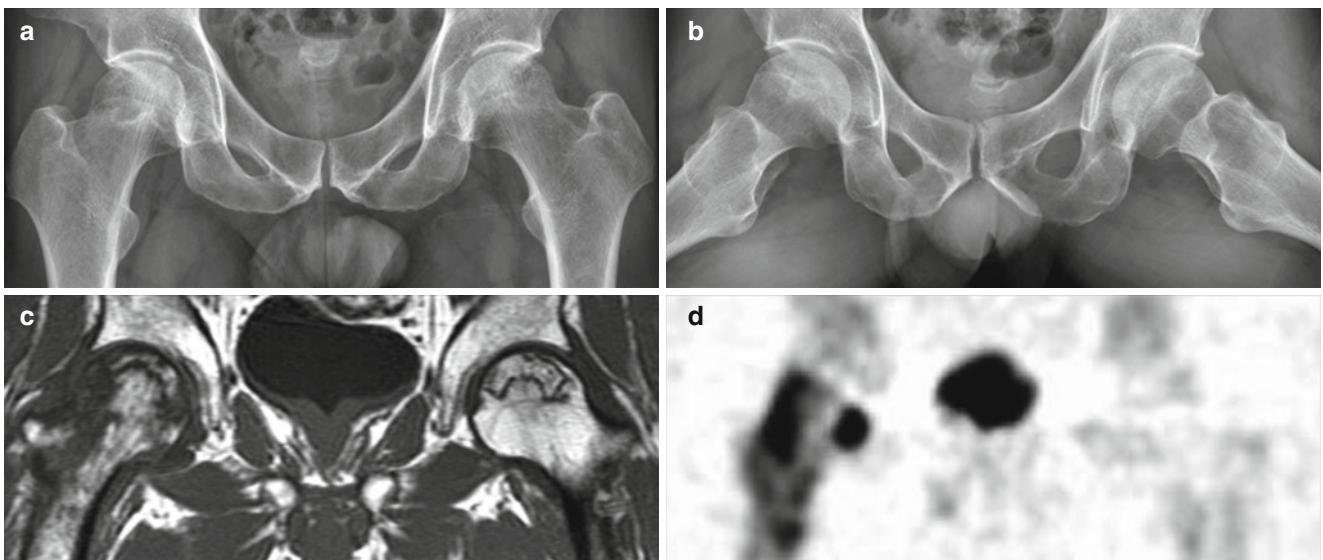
ON (ARCO stage II) of both femoral heads in a 55-year-old male patient. (a) Anteroposterior view of hip joints shows radiolucencies of both femoral heads with curvilinear sclerosis. (b) Frog leg lateral view shows round contours of both femoral heads. (c) T1-weighted
